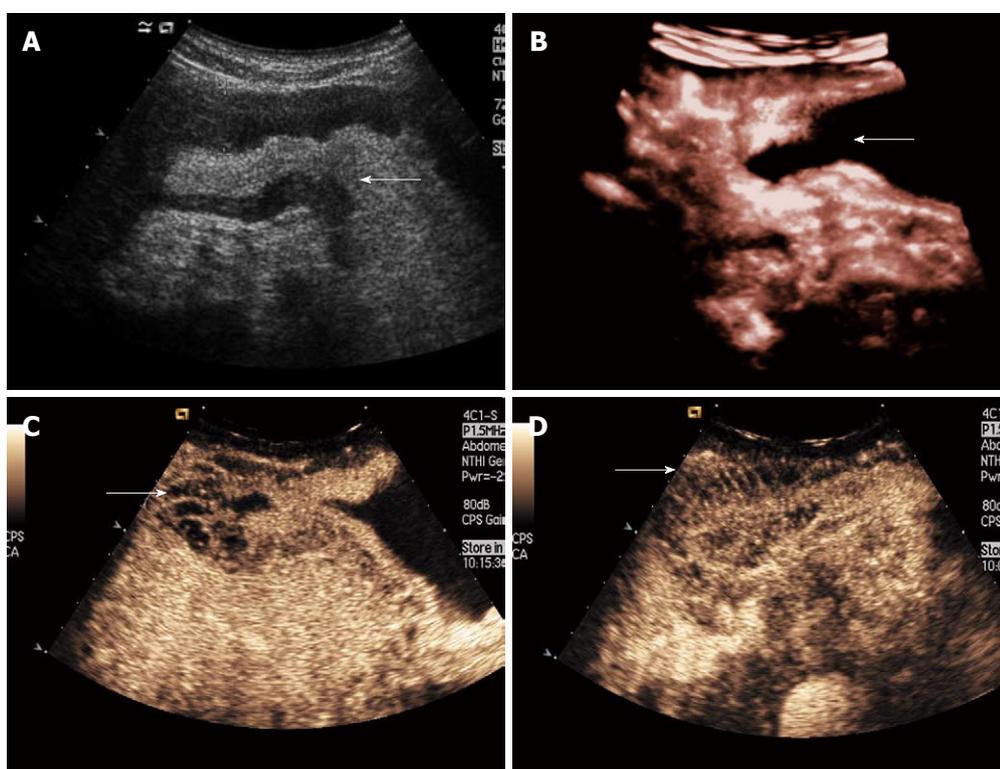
Double contrast-enhanced ultrasound imaging of gastric stromal tumor. A: Two-dimensional double contrast-enhanced ultrasound (DCUS) images displayed a anechoic mass into the gastric cavity in oral contrast ultrasonography (right figure), from which we hardly judged whether it was cystic or solid lesion; but the intravenous contrast imaging (left figure) showed there was contrast agent enhancement in the focus of infection (arrow); B: Three-dimensional DCUS imaging displayed the tumor elevated to the gastric cavity (arrow).
